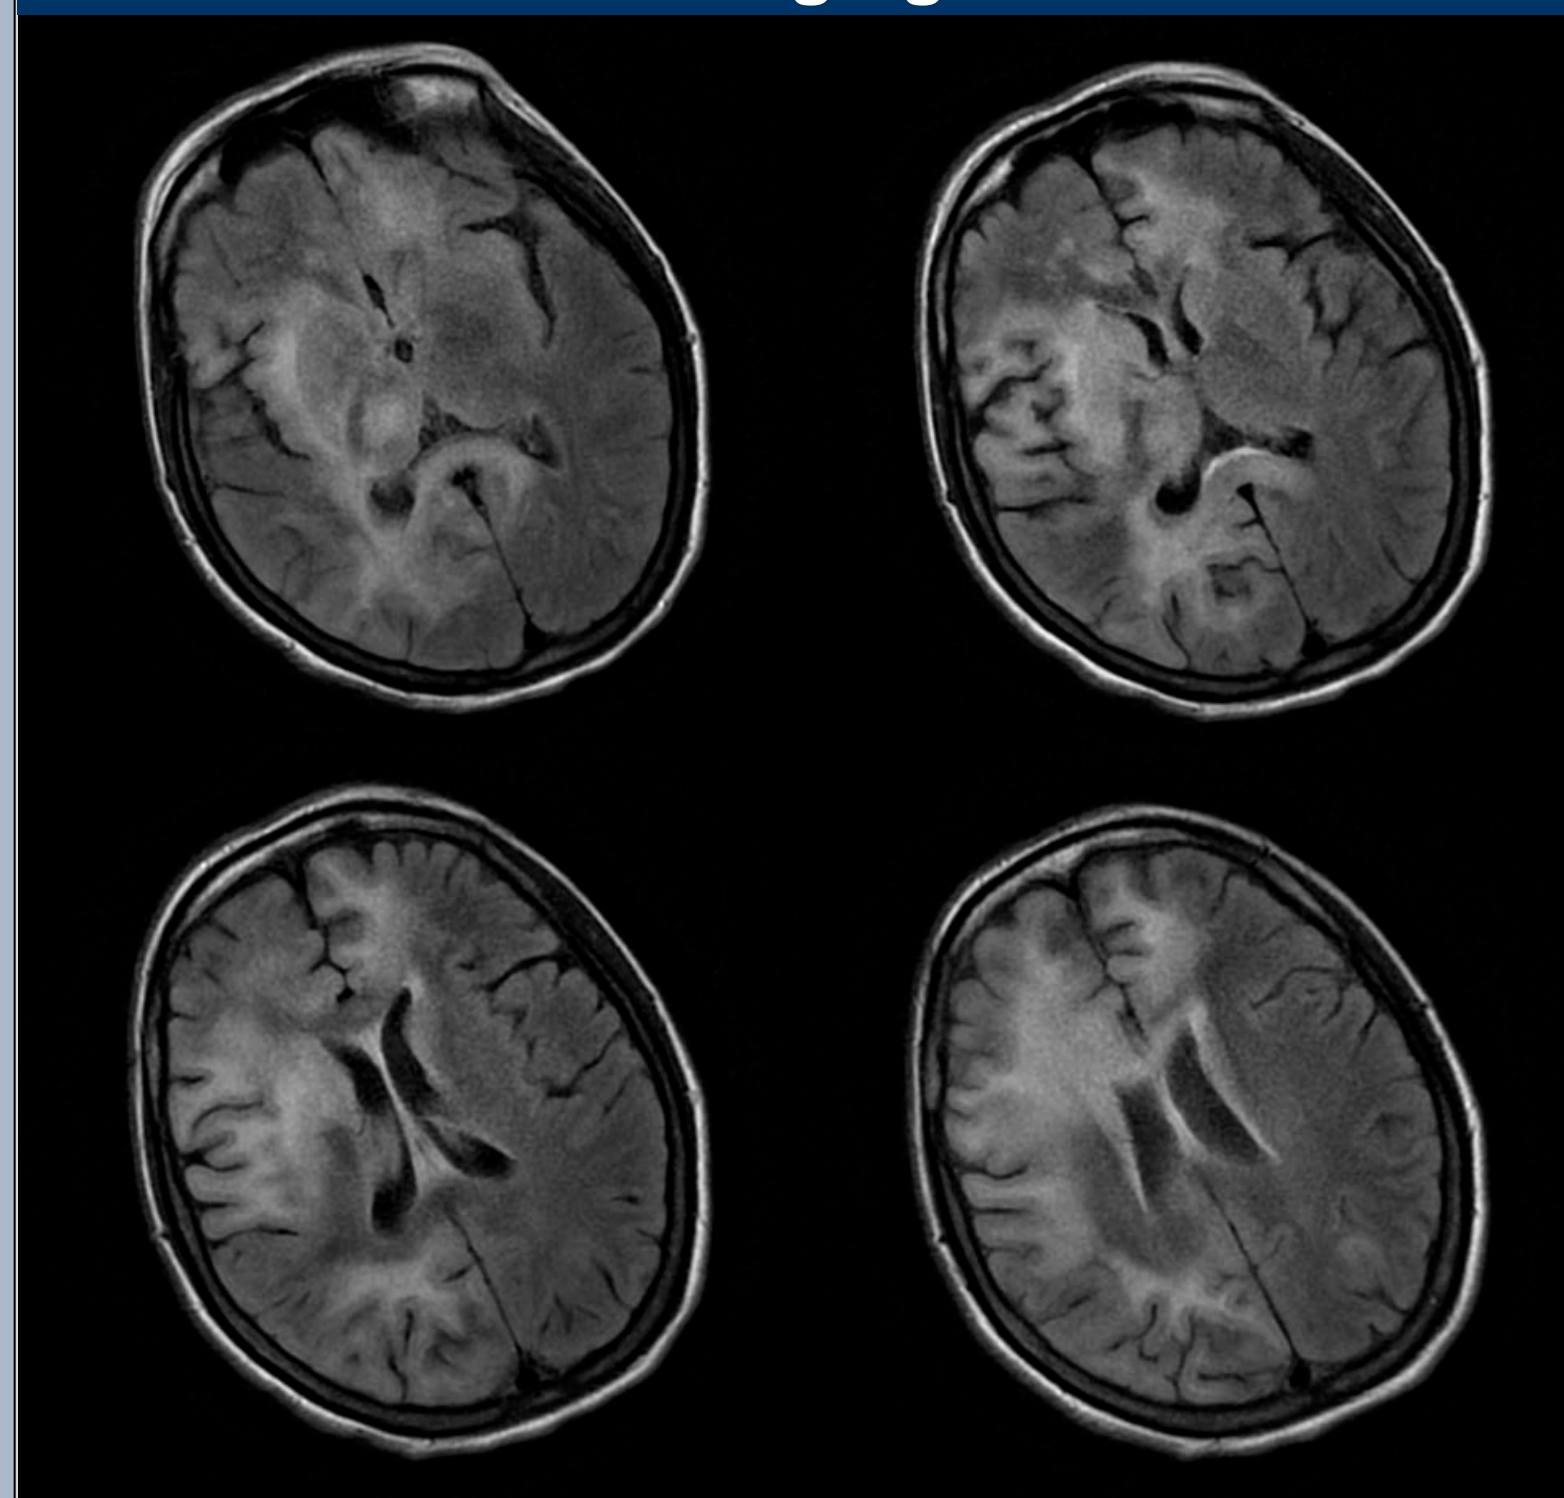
MRI of the brain showing diffuse confluent increased T2 signal in the deep white matter in the entire right hemisphere and in the left frontal lobe and deep gray matter. The corpus callosum is also involved.
